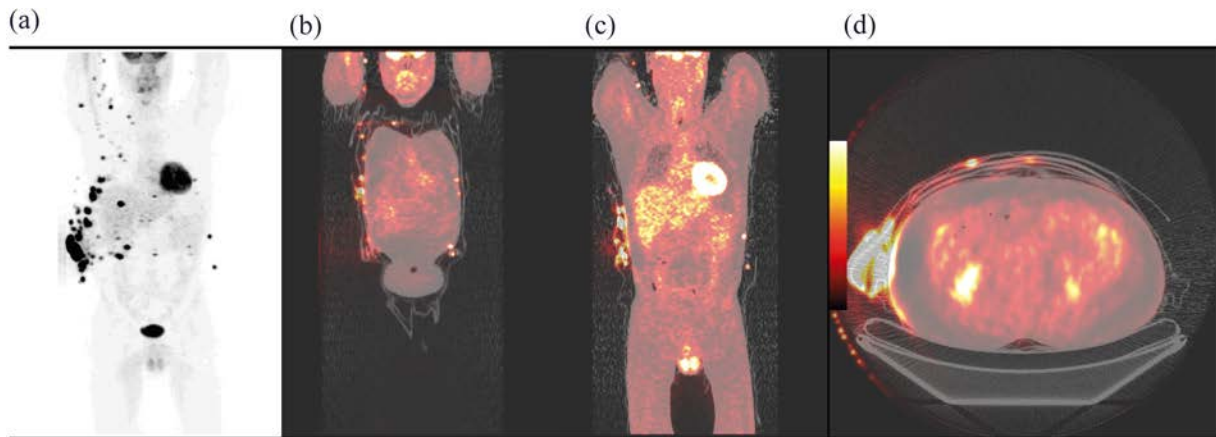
Extensive contamination seen on maximum intensity projection PET and localized to extra-corporal foci only on fused AC-PET/CT images. (a) Maximum intensity projection; (b) and (c) two selected coronal slices; (d) a transaxial slice through the contamination site.
